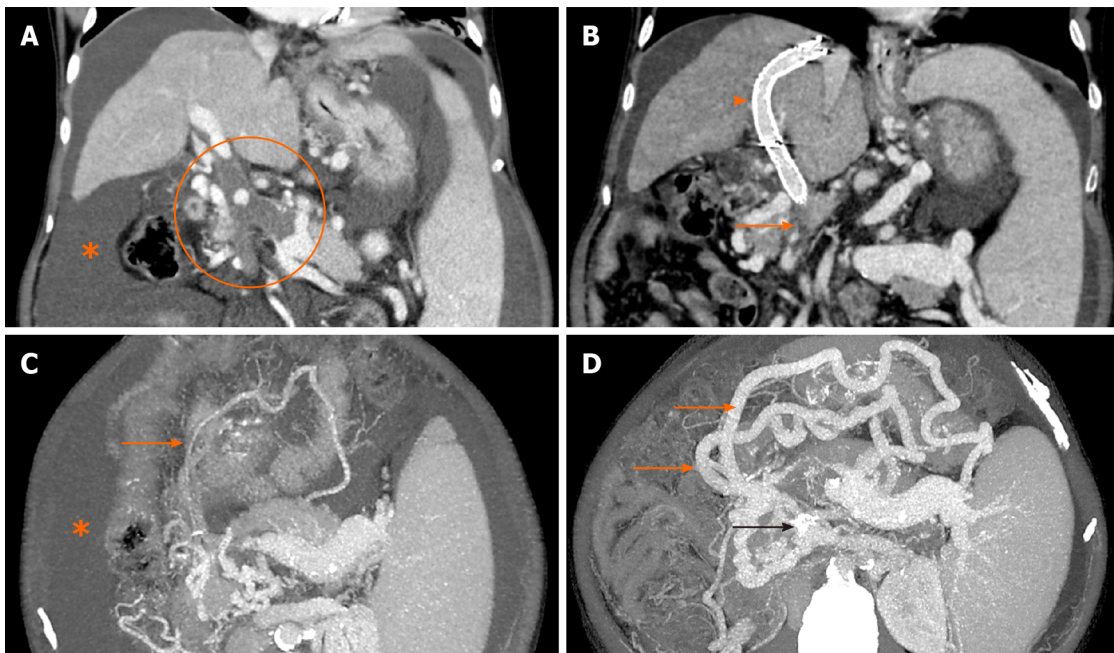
Contrast-enhanced computed tomography image. A: Coronal image showing bland occlusive thrombus involving the main portal vein, superior mesenteric vein (SMV) and splenic vein (encircled) with gross ascites (asterisk); B: Image taken 2 wk after transjugular intrahepatic portosystemic shunt (TIPS) shows the stent in situ (arrowhead) with its distal end in one of the major tributaries of SMV. The main trunk of SMV (solid arrow) and splenic vein could not be fully recanalized during TIPS. Trans-splenic access was not taken due to gross ascites; C and D: Corresponding axial images show marked enlargement of the gastroepiploic collaterals (solid orange arrows) arising from the patent portion of splenic vein at splenic hilum draining through the TIPS stent (black arrow in D) into the portal venous system. Note the significant regression of ascites on the follow up scans.
